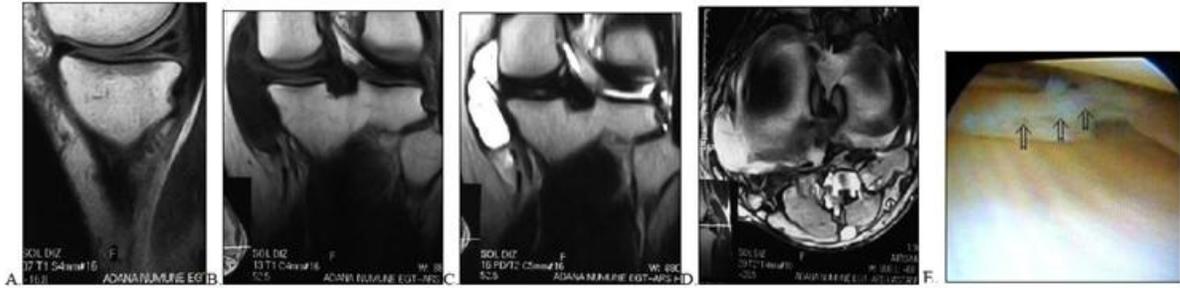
Horizontal tear at the medial meniscus of the left knee. Sagittal T1W (A) and coronal T1W (B) MRI images. There is a septated cystic structure (parameniscal cyst) at the near vicinity of the posterior horn of the medial meniscus. The cyst appears hypointense on the coronal T1W image (B), whereas it is seen as a hyperintense structure on the T2W coronal (C) and T2*W axial (D) images. There is also an arthroscopic view (E).
